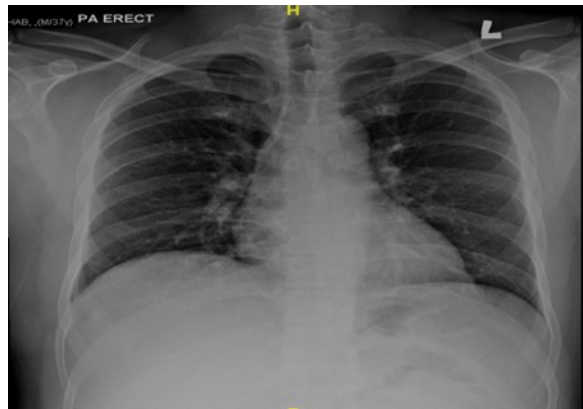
Normal chest x-ray. (click to enlarge image)
